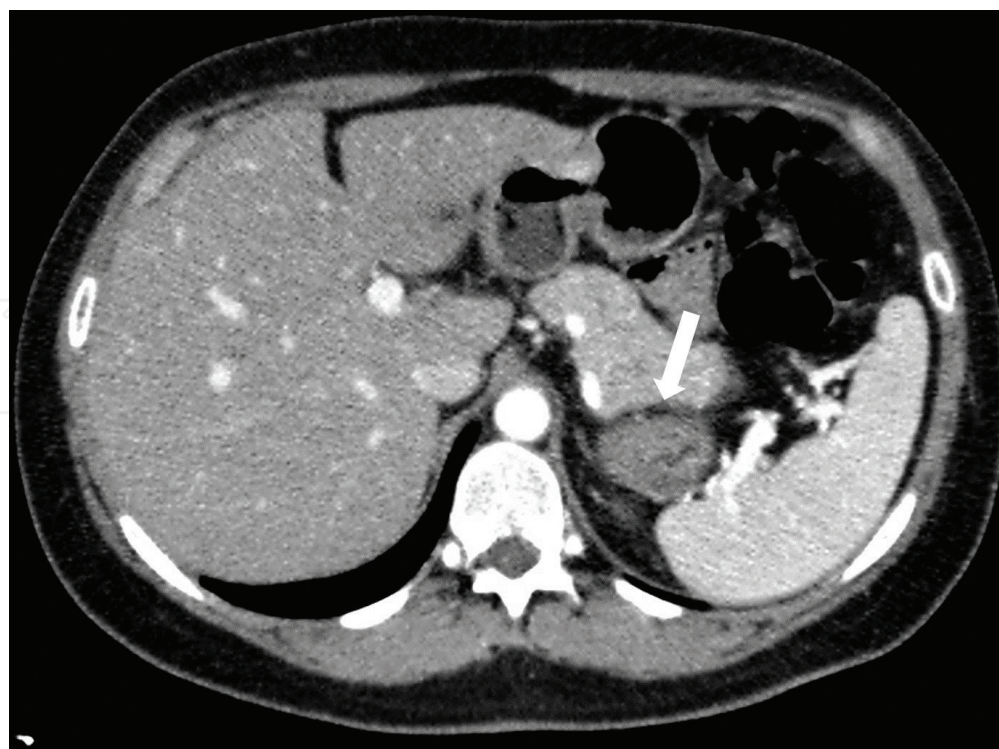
CT: left adrenal incidentaloma.
